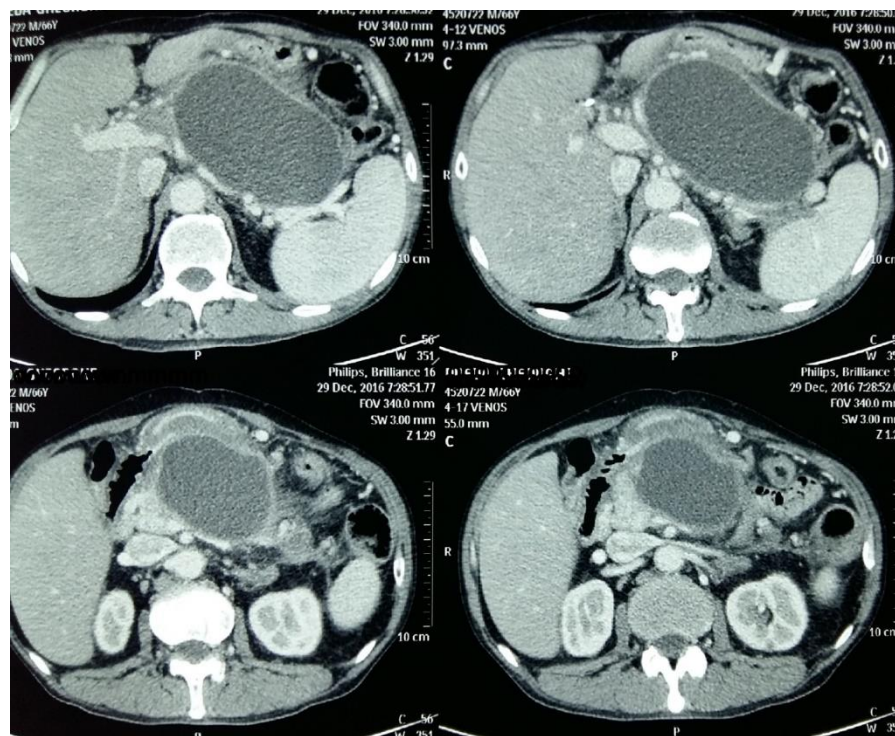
CT scan (axial section) shows a homogenous cystic mass to the body and tail of the pancreas, compressing the adjacent structures.
